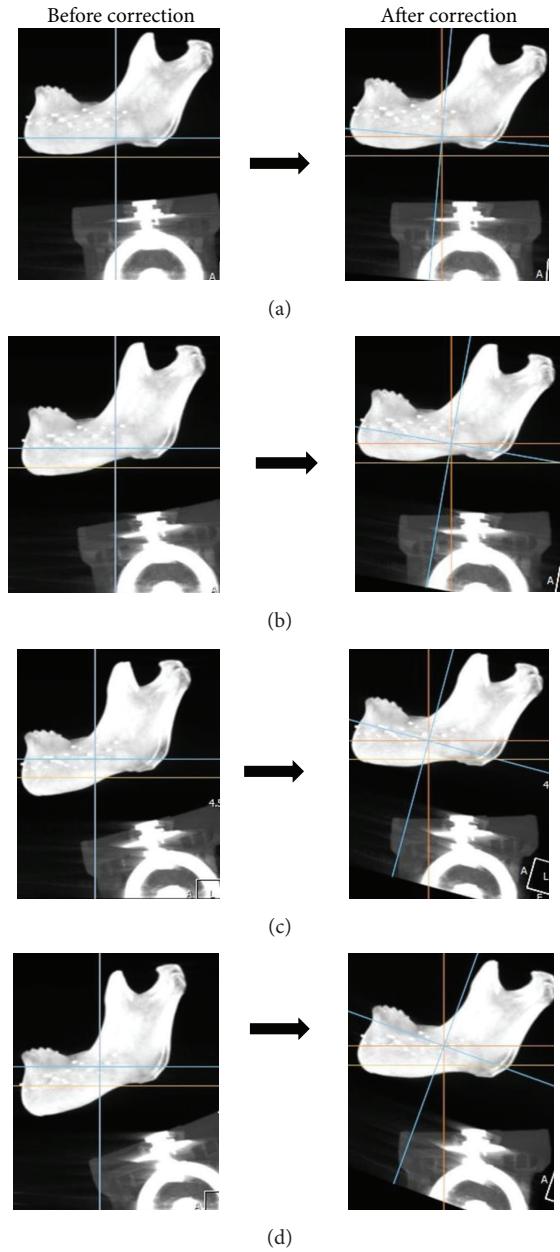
CBCT images before and after the correction of the mandibular planes. The inferior border of the mandible (mandibular plane) was positioned at 5-, 10-, 15-, and 20-degree angles relative to CBCT scanning table, and the mandibular planes at different angles were corrected to the 0-degree position using the software. (a) Five-degree angle location. (b) Ten-degree angle location. (c) Fifteen-degree angle location. (d) Twenty-degree angle location.
